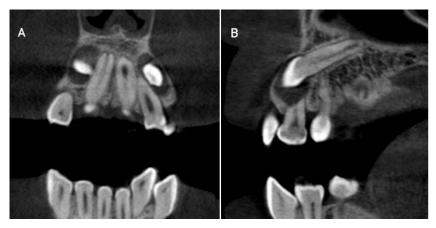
CBCT exam results (A) frontal and (B) lateral
